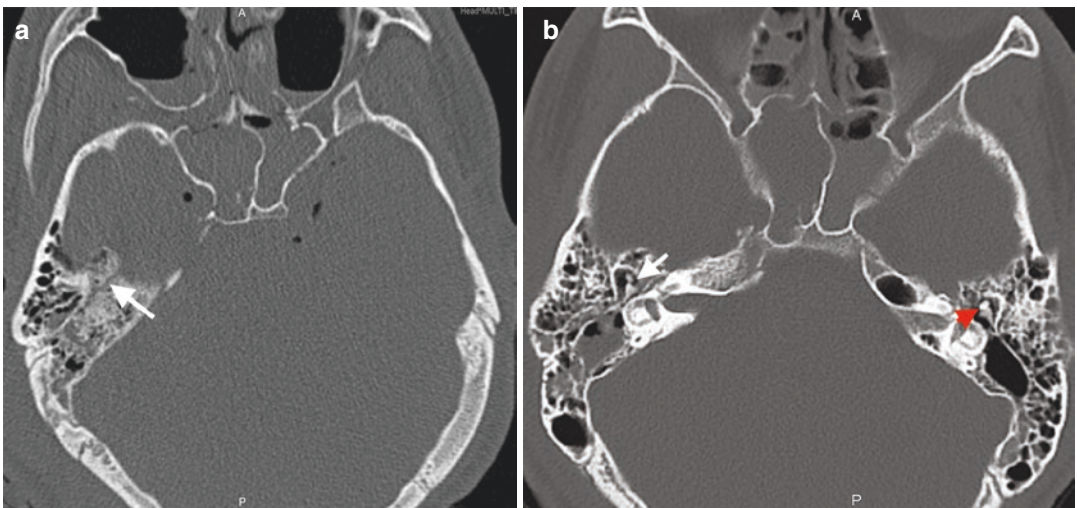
Incudomalleolar dislocation. (a) Axial CT image demonstrates right temporal bone fracture (arrow) with oblique orientation. (b) Ice cream cone appearance (red arrowhead) represents normal incudomalleolar joint
